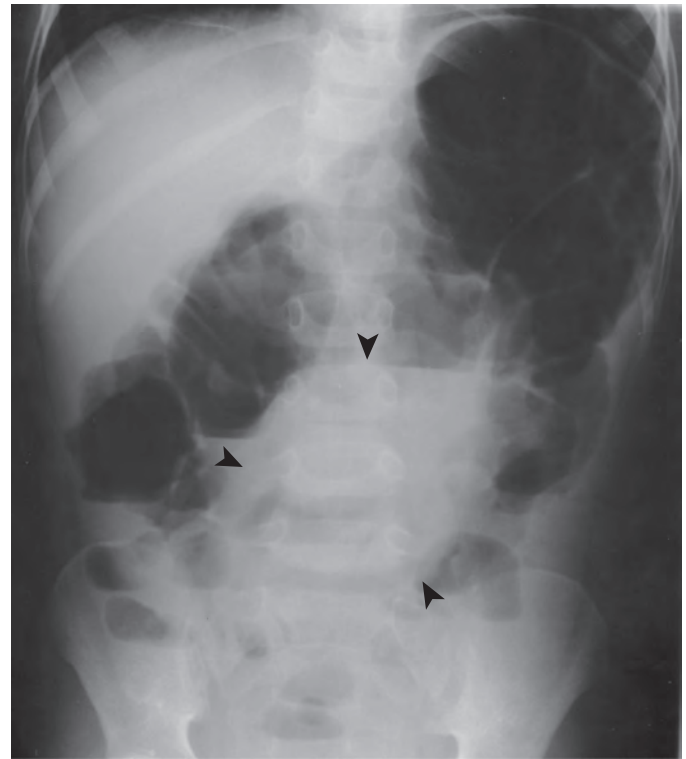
Ectopic wandering spleen. A plain radiograph demonstrates gaseous distention of the colon in the left upper quadrant, with no mass effect in the expected location of the spleen. In the midabdomen, the ectopic spleen (arrowheads) displaces the bowel, as confirmed on cross-sectional imaging. Air-fluid levels are seen in the small bowel.
